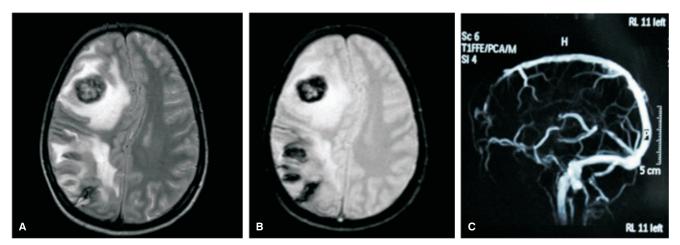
Magnetic resonance imaging (MRI) and magnetic resonance venography (MRV). A. T2-weighted axial image of the patient shows heterogenous intensity area of central hyperintensity area with surrounding hypointensity in right parietal region with extensive white matter oedema; B. FFE T2 imaging shows blooming at the respective regions suggesting intracranial haemorrhage; C. MR venography of the patient showed no abnormalities.
